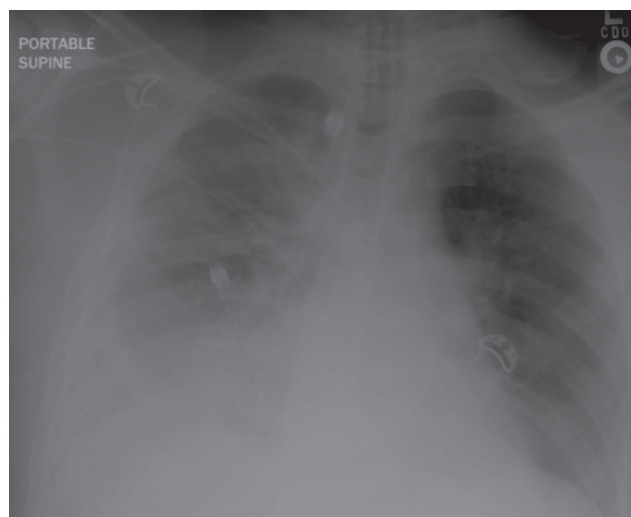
Patient with acute respiratory distress syndrome with bilateral patchy infiltrates on chest x-ray.
